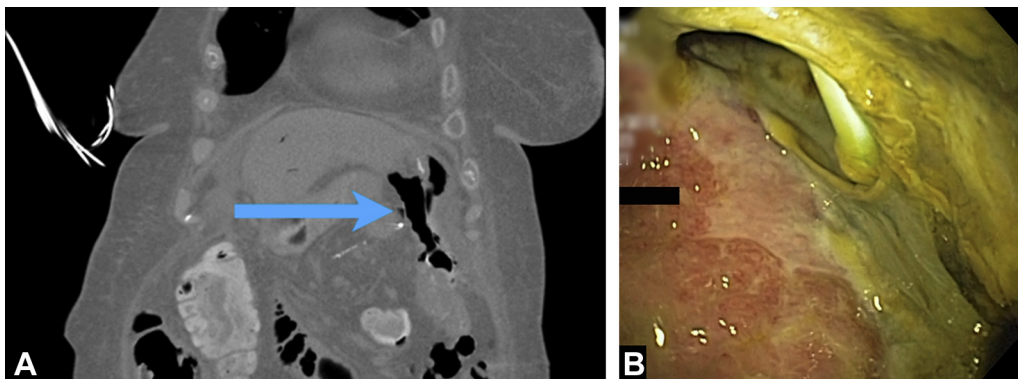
In patient 1, (A) CT scan demonstrating dehiscence of gastric suture line (*blue arrow*). B, Confirmed endoscopically.
